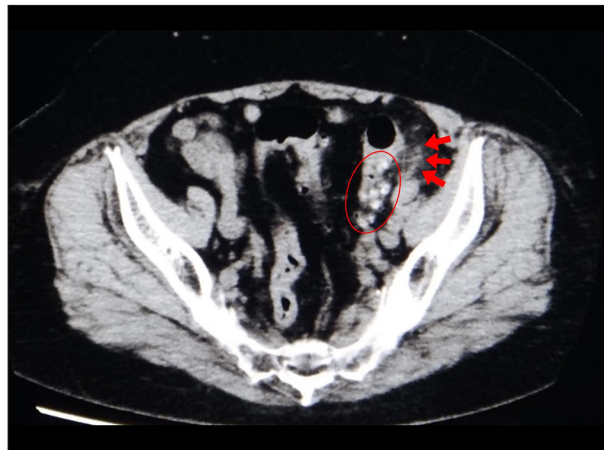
Plain computed tomography findings on the first visit. The scan shows inflammation around diverticula in the sigmoid colon. The diverticula are circled and its inflammation is indicated with arrows.
